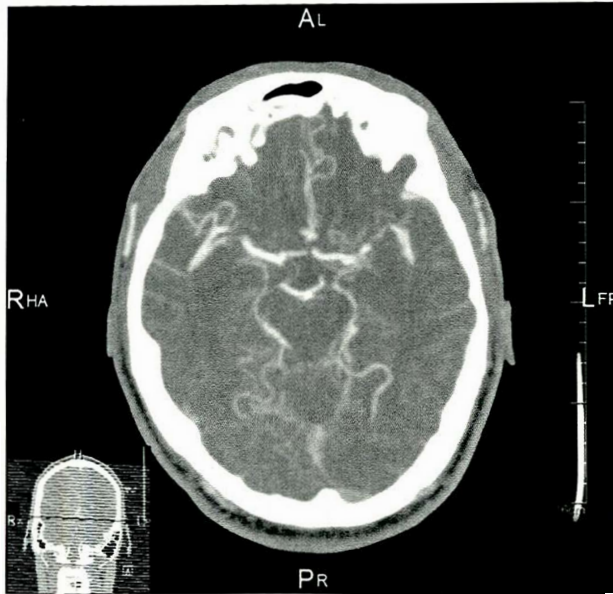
CT angiogram revealing mild stenosis of the distal left internal carotid artery and severe focal stenosis versus occlusion of the proximal left middle cerebral artery. There has been development of lenticulostriate collaterals as may be seen with Moyamoya pattern of involvement.
